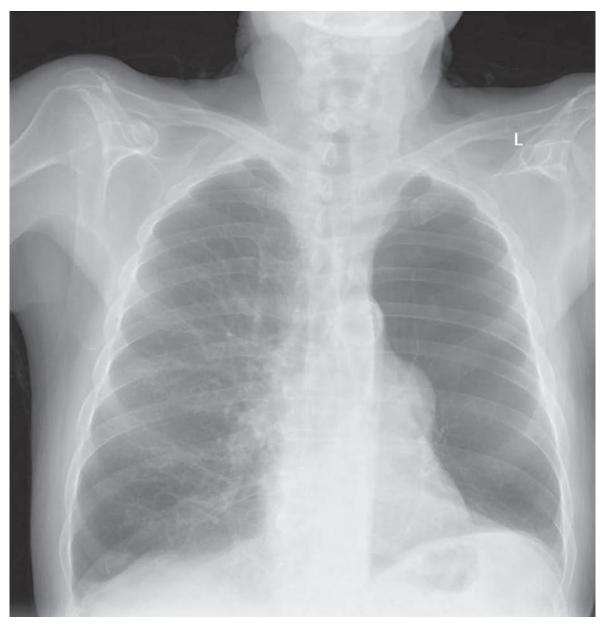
Admission chest X-ray
